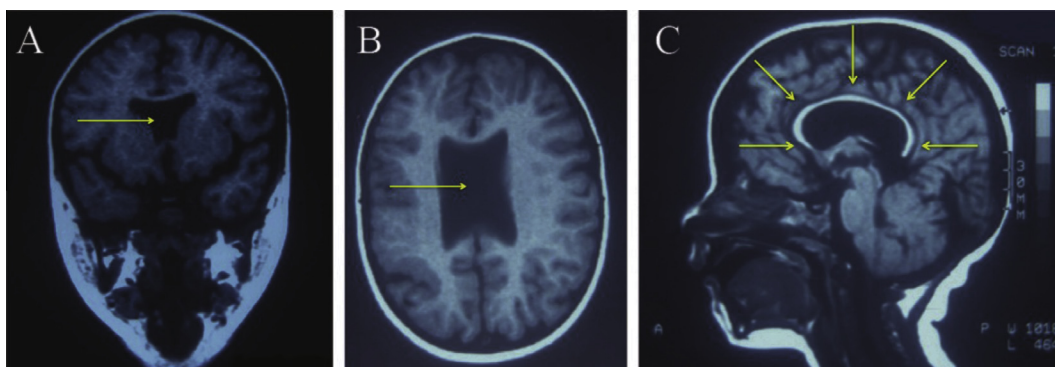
Septo-optic dysplasia (MRI). (A) and (B) Septum pellucidum agenesis (yellow arrow); and (C) corpus callosum atrophy (yellow arrows).
